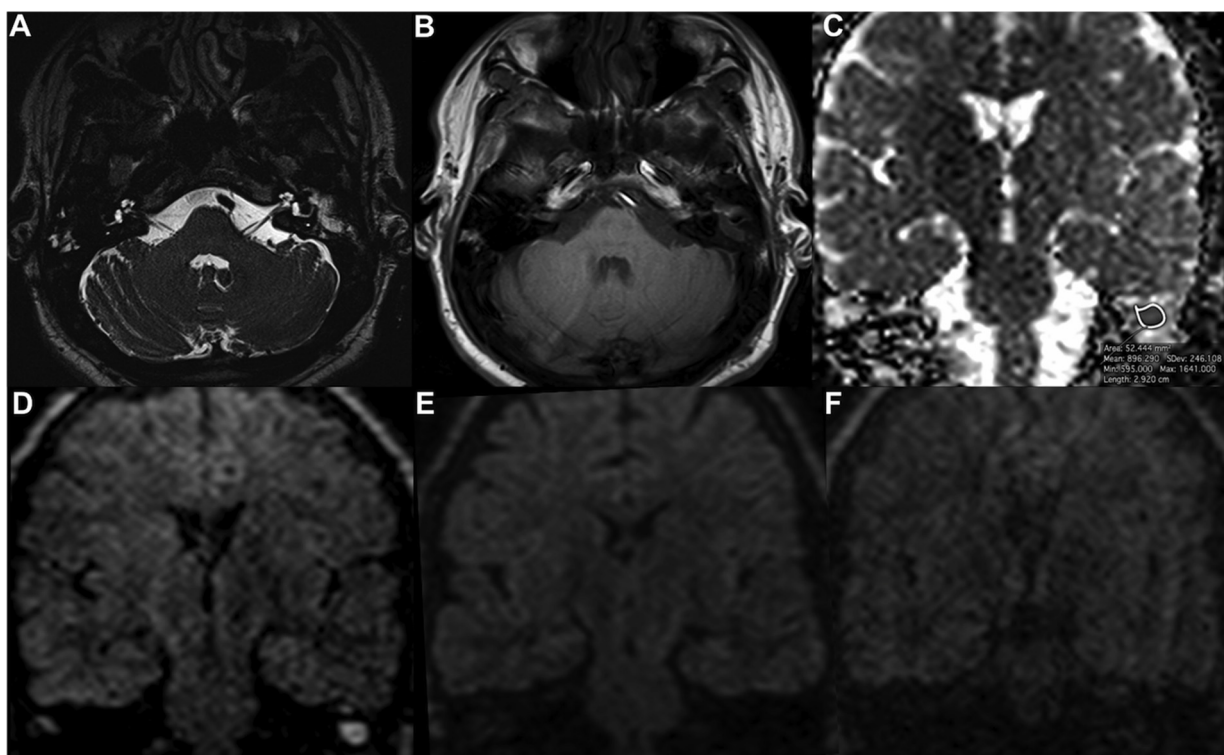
Left middle ear cholesteatoma in a 55-year-old man with no evidence of recurrence at 3 years-long post-operative follow-up. (A–D) Baseline MRI examination: (A) axial T2w 3D TSE; (B) axial T1w SE; (C) coronal ADC map showing the co-registered ROI within lesion's margins; (D) coronal MSH non-EPI DWI. (E) Coronal MSH non-EPI DWI 3 months after first-look surgery, showing absence of residual cholesteatoma. (F) Coronal MSH non-EPI DWI 36 months after first-look surgery, confirming no evidence of recurrence.
